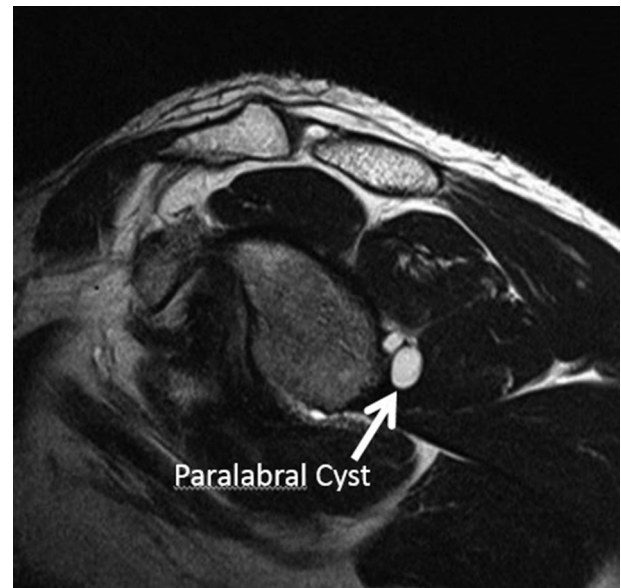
Sagittal oblique magnetic resonance imaging view of the en face glenoid showing the location of the paralabral cyst on the clock face of the glenoid to plan for the location of the limited capsular window (arrow). This view of the cyst is a critical component of this technique because it allows the surgeon to know the exact location of the cyst as it abuts the capsule. The location of the cyst as it abuts the capsule will determine the specific location of the limited capsular window that allows access to the cyst. In this view, the loculated cyst can be seen just off the posterior-inferior aspect of the glenoid, at roughly the 4-o'clock position.
